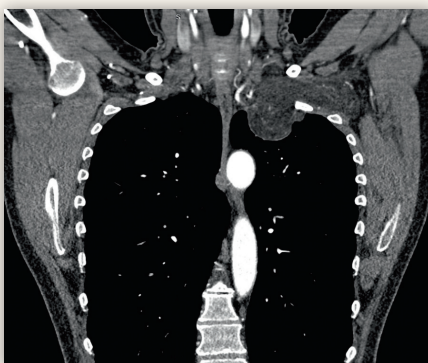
Coronal reformat of the contrast-enhanced CT, demonstrating the hibernoma protruding into the thoracic cavity medial from the first rib on the left side.
